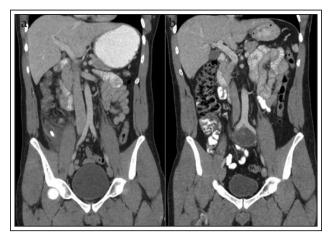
a) Coronal CT scan 15 months prior to presentation. b) Presacral tumor inferior to the bifurcation of the abdominal aorta measuring approximately 5.0 cm x 3.8 cm x 4.2 cm.
